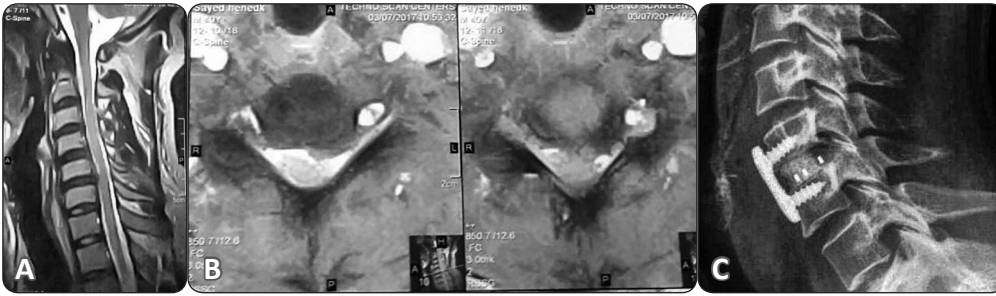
A and b: preoperative MRI cervical spine showing CDP C5-6. C: ACDFP was done and follow up X-ray cervical spine after 6 months showing bone fusion.
